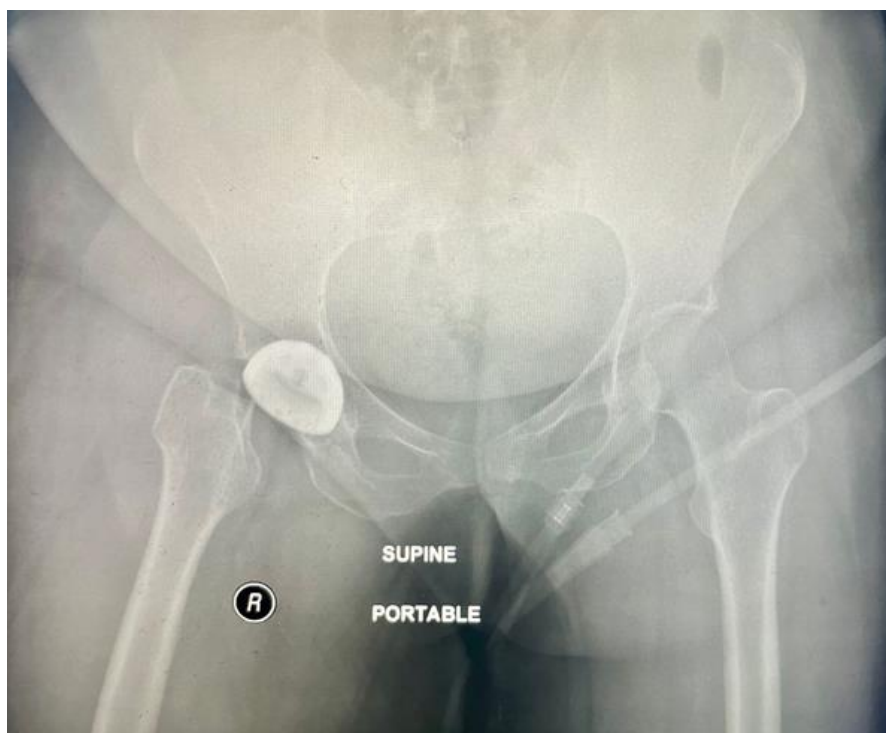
Post-operative AP radiograph of the pelvis (post 1st procedure) showing the implantation of the acetabular cup.
